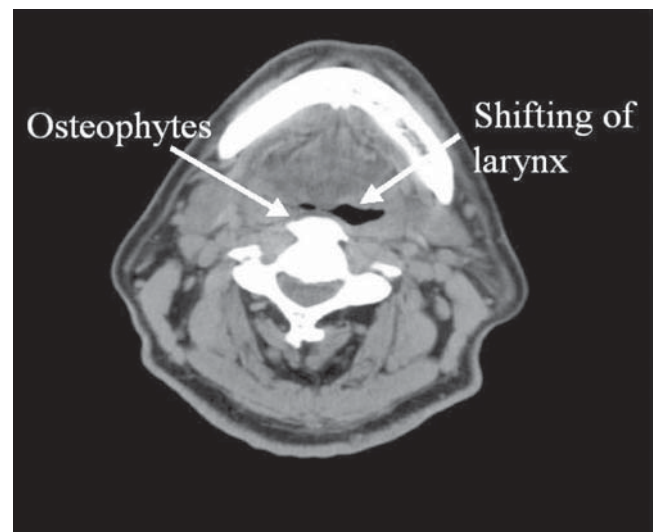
Computed tomography imaging of cervical spine of the patient, showing osteophytes lying on the anterior surfaces of the vertebrae
